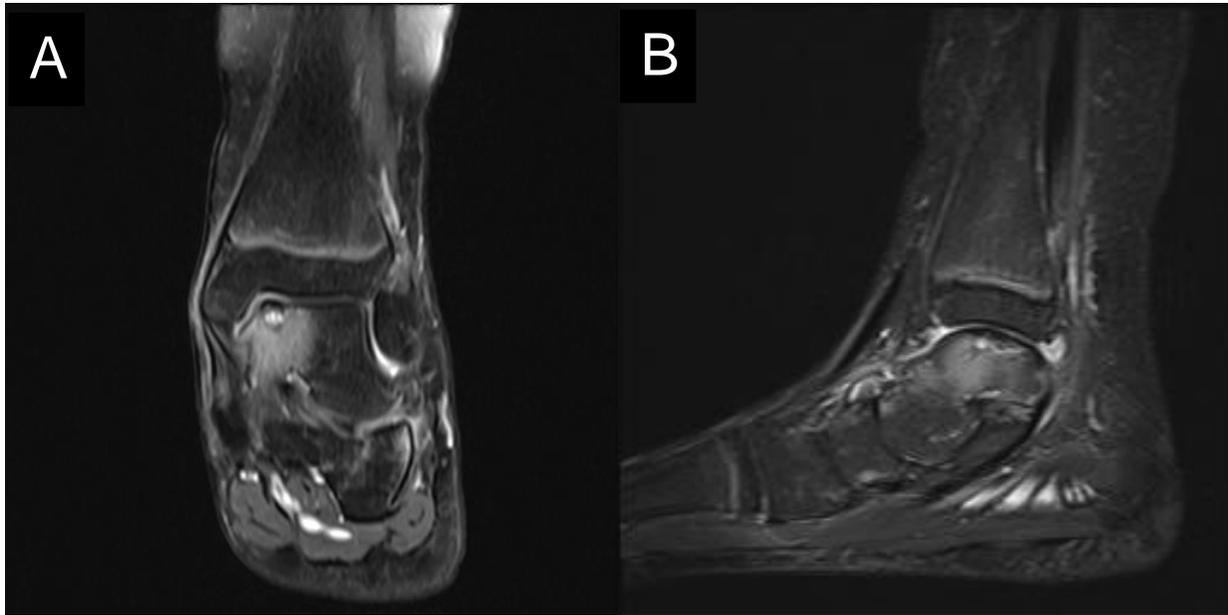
Pre-operative A) Coronal and B) Sagittal plane MRI demonstrating large medial talar dome lesion/defect with significant marrow edema & reaction.
